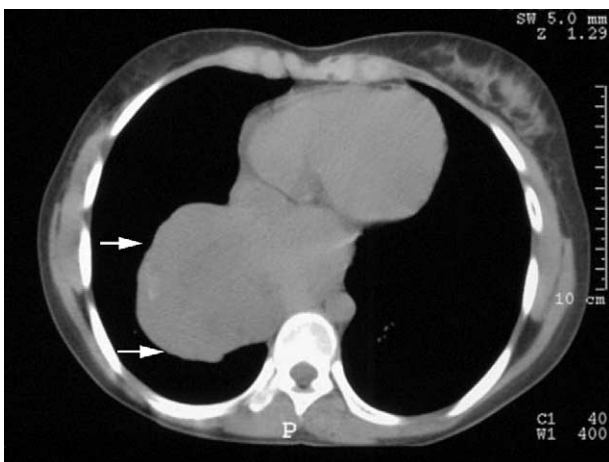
CT scan of the 15-year-old girl confirms the presence of a massive distal esophageal leiomyoma (arrows).
